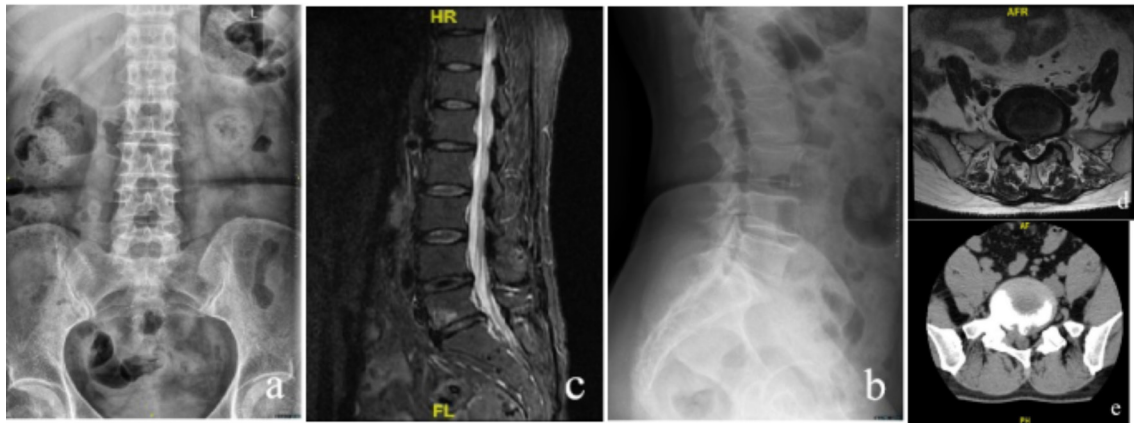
a-b, preoperative lumbar frontal and lateral radiographs showing degenerative changes in the lumbar spine; (c-e) MRI and CT of lumbar spine showed L5/S1 disc herniation and endplate inflammation, CT showed small joint hyperplasia, lateral sphenous fossa stenosis, posterior margin bone formation, and disc herniation compressing the dural sac.
